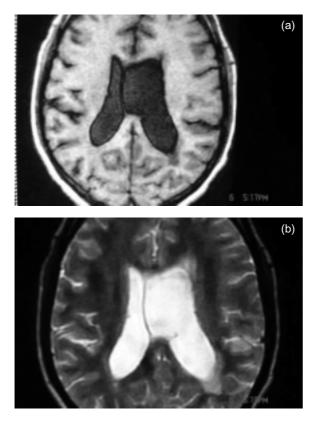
Preoperative magnetic resonance imaging (1a, T1 contrast, 1b T2 weighted) showing left lateral ventricular cyst.
